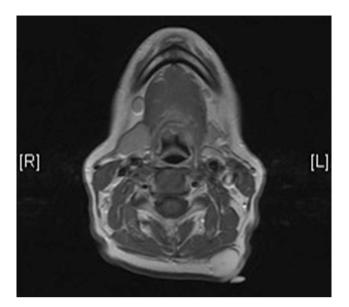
T1-weighted contrast enhanced MRI image of a 2 cm dermatofibrosarcoma protuberans of the superficial posterior left neck
